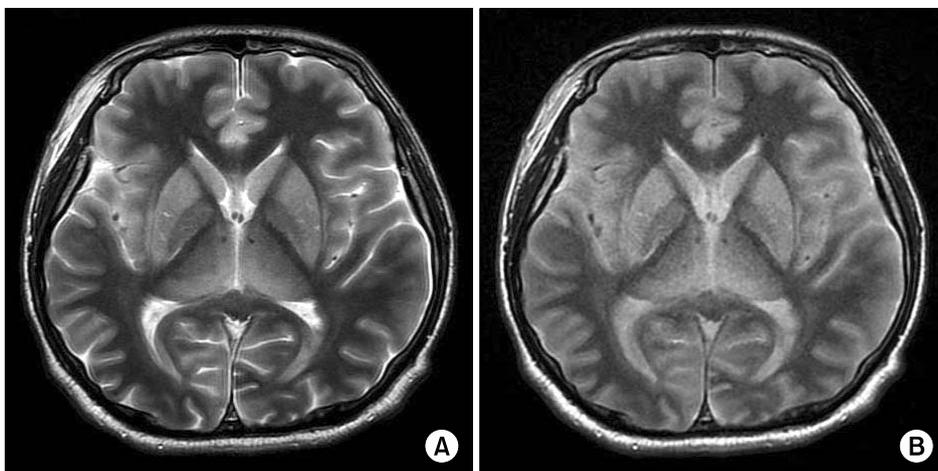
Brain magnetic resonance imaging at the eighth hospital day shows aggravated meningoencephalitis with hypoxic brain injury. T2-weighted image (A) and fluid-attenuated inversion recovery sequence (B) shows hyperintense signals in the cortex of both cerebral hemispheres, basal ganglia and thalamus.
